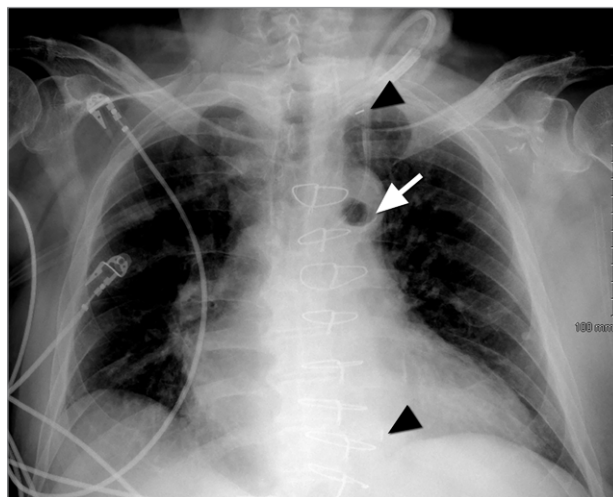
Chest radiograph (anteroposterior view) shows a circular air-filled space in the aortic knob (arrow). Arrowheads point to the intra-aortic balloon pump radiopaque markers.
